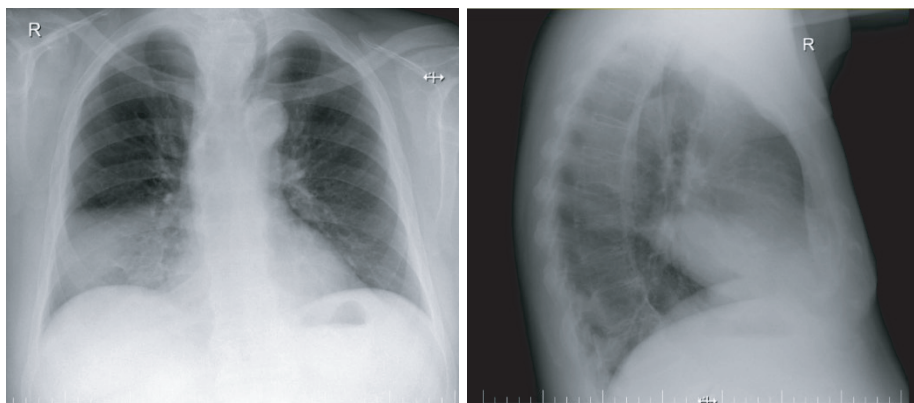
Chest radiograph postero-anterior view (PA) and right lateral view (LLR) incidence: cervical formation with mass effect on the trachea, lung condensation located in the middle lobe.
